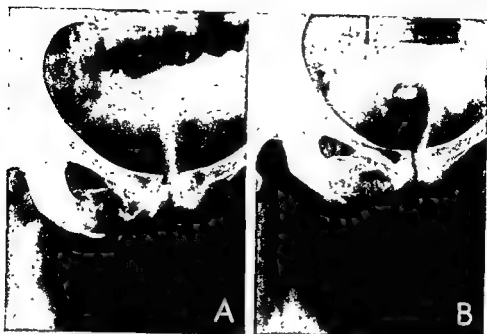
A, Giant cell tumor of pubis. B, Appearance nine years later, showing healing following roentgen therapy.
